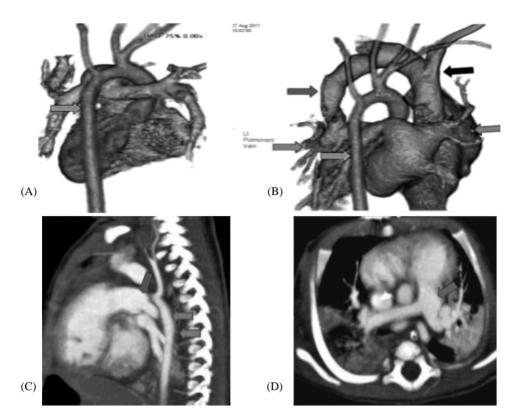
(A,B) 3D reformatted images showing hypoplastic descending Aorta (yellow arrows) and Left superior pulmonary vein (light blue arrow) draining into PLSVC (green arrow). Right atrium is labeled by (red arrow) and SVC labeled by (black arrow). (C) Sagittal reconstructed CT image. (D) Axial MDCT image showing hypoplastic descending Aorta (red arrows) and congested and dilated main pulmonary artery (green arrows).
